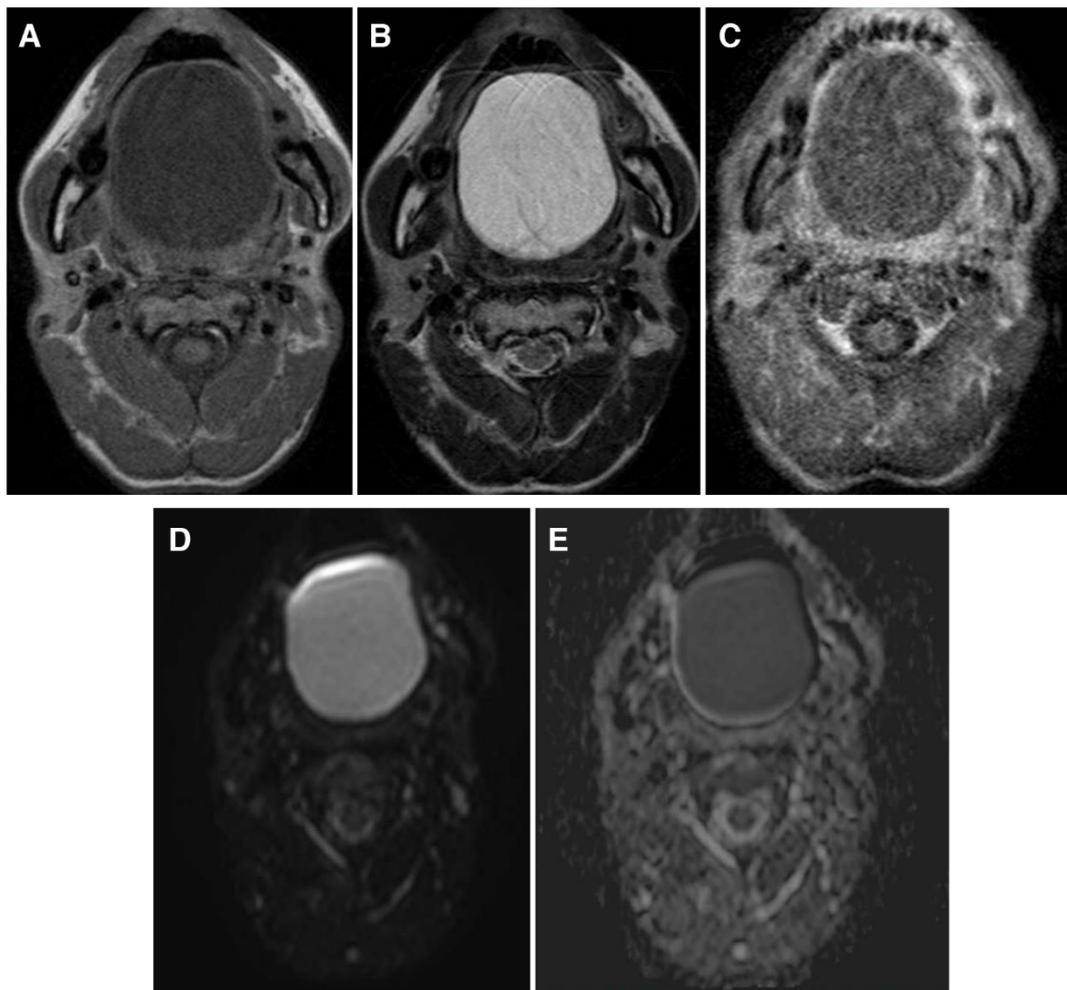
MRI findings. (A) Low signal at T1. (B) High signal at T2. (C) Contrast effect only around lesion. (D) Diffusion weighted image. (E) Apparent diffusion coefficient image.
